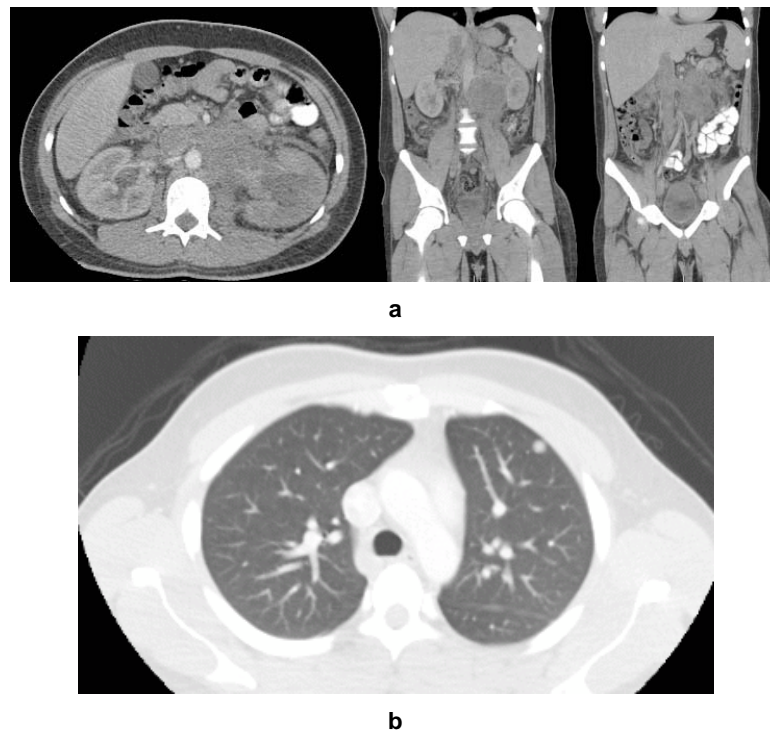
a and b Contract enhanced CT.
